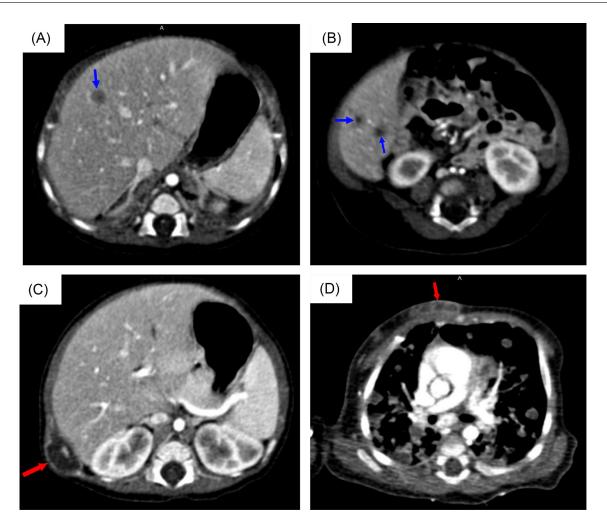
(A-D) Axial postcontrast CT of the chest and upper abdomen showing hypo-dense rim enhancing collections in the anterior and lateral chest wall (red arrows) and multiple hypo-dense peripherally enhancing lesions in the right liver lobe (blue arrows).
